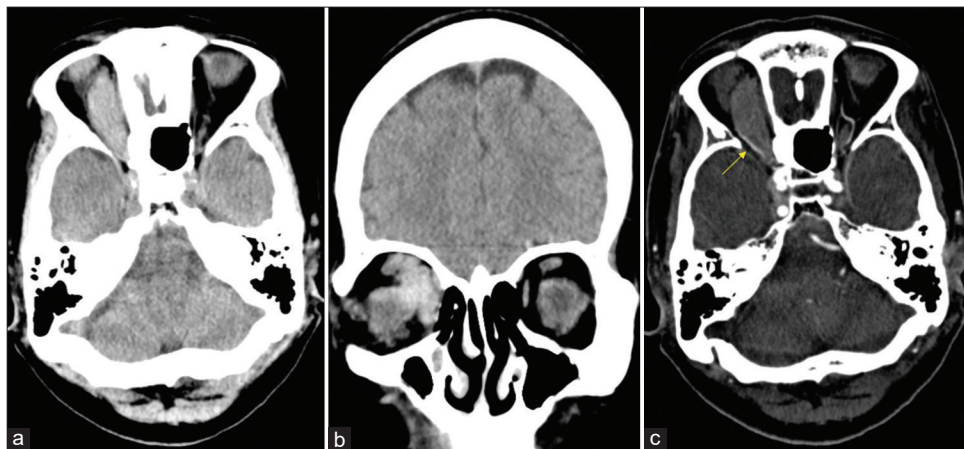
(a and b) Head computed tomography (CT) revealed a mass superior to the medial side of the right orbit. (c) CT angiography revealed an ophthalmic artery (arrow) outside the mass.
